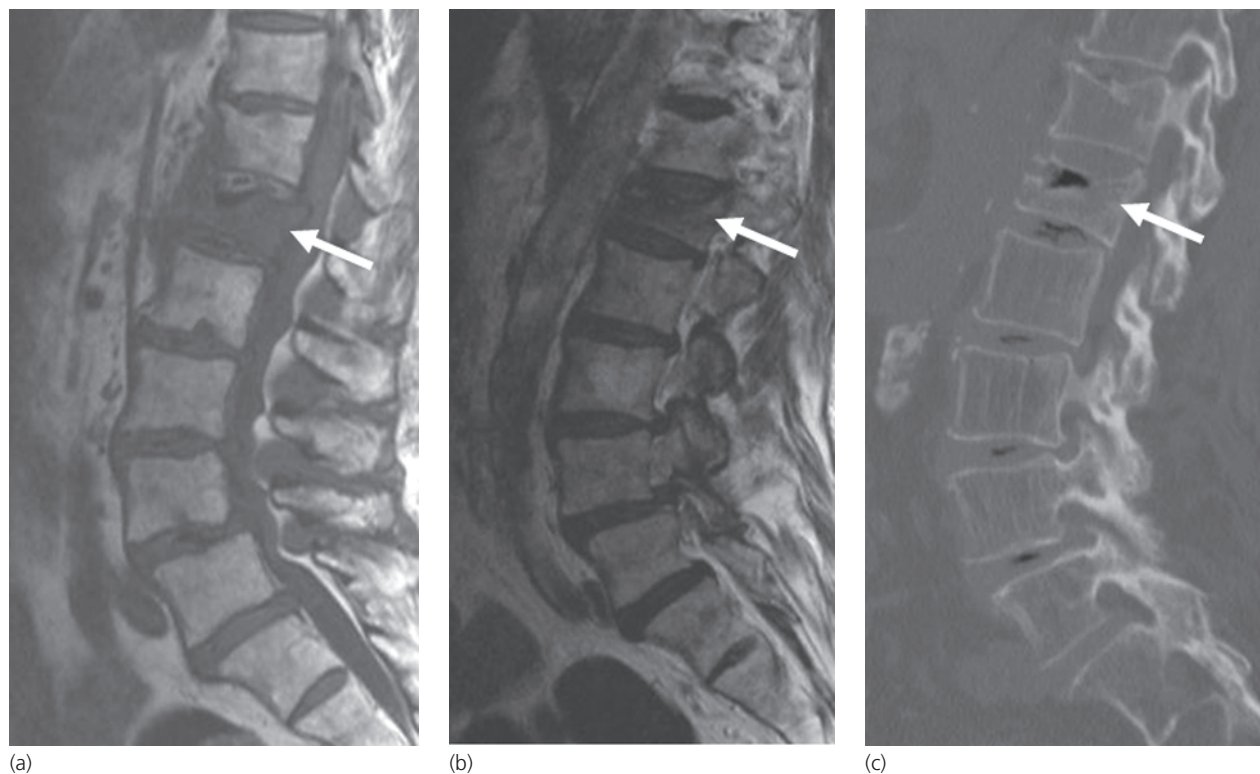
Insufficiency vertebral body fracture. (a) T1- and (b) T2-weighted images show L1 low marrow signal with superior endplate compression and horizontal fracture line (arrow in b). (c) Sagittal CT reformatted image shows gas in the fracture cleft (arrow) compatible with an insufficiency fracture.
